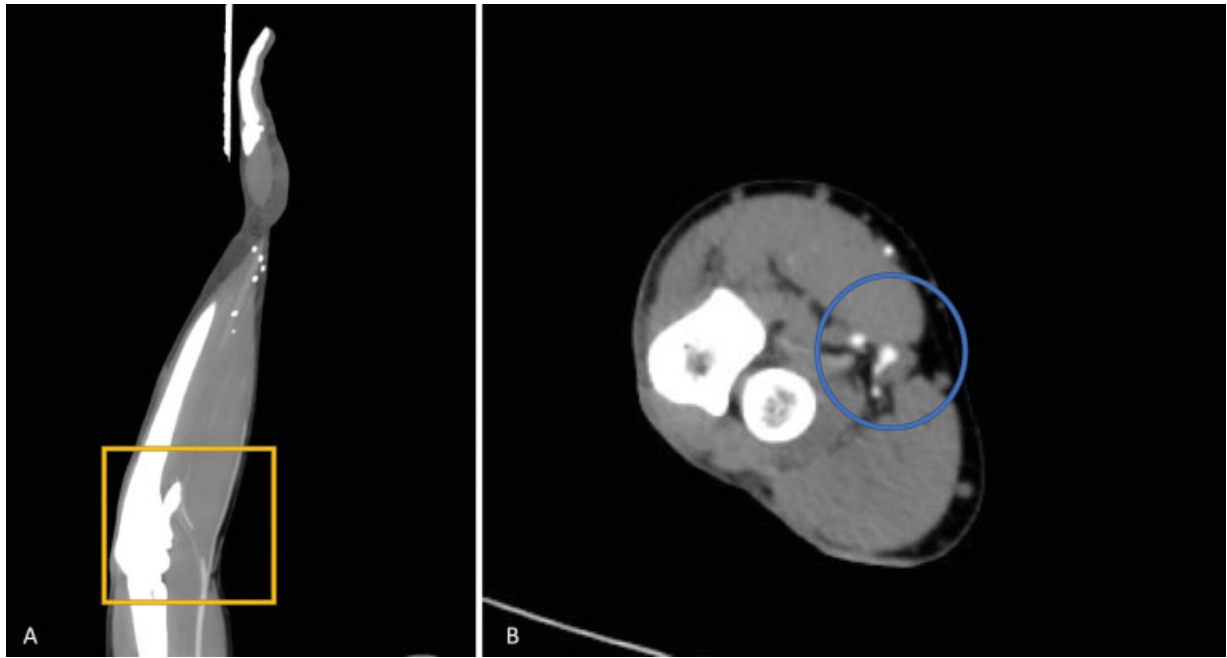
Computed tomography view of the antecubital region. (A) Coronal section (yellow square: brachial artery bifurcation, separation of radial and ulnar artery). (B) Axial section (blue circle: brachial artery bifurcation, separation of radial and ulnar artery).
